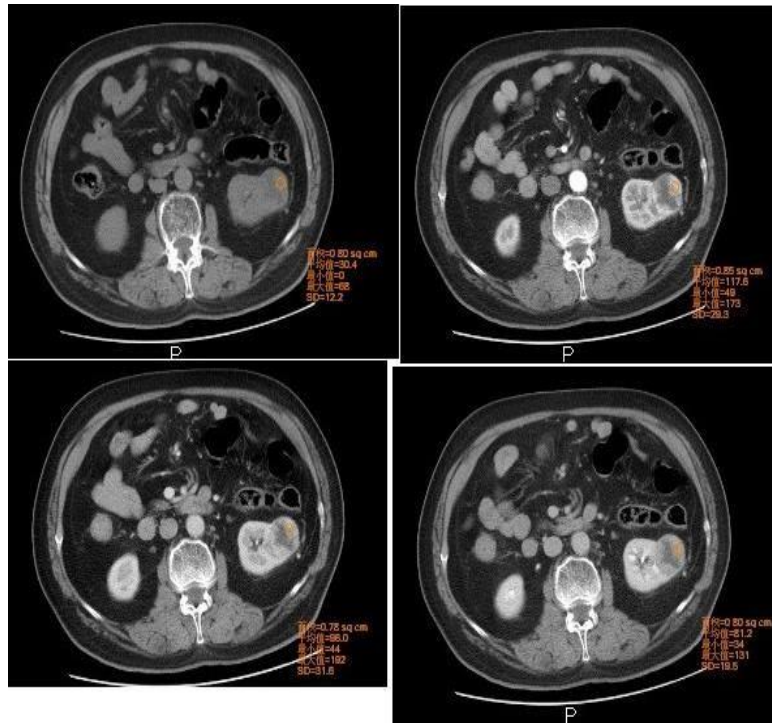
Male, 78 years, CCRCC in left renal (A). A solid round heterogeneous mass with clear boundary in un-enhancement with Ct value of 30HU;(B). In the corticomedullary phase mass shows obviously heterogeneous enhancement with necrosis present with high CTvalueof117HU. (C). In the parenchymal phase, the CT value of the same location was 96HU. (D). In the excretion phase, the Ct value was 80HU showed as delayed phase.
